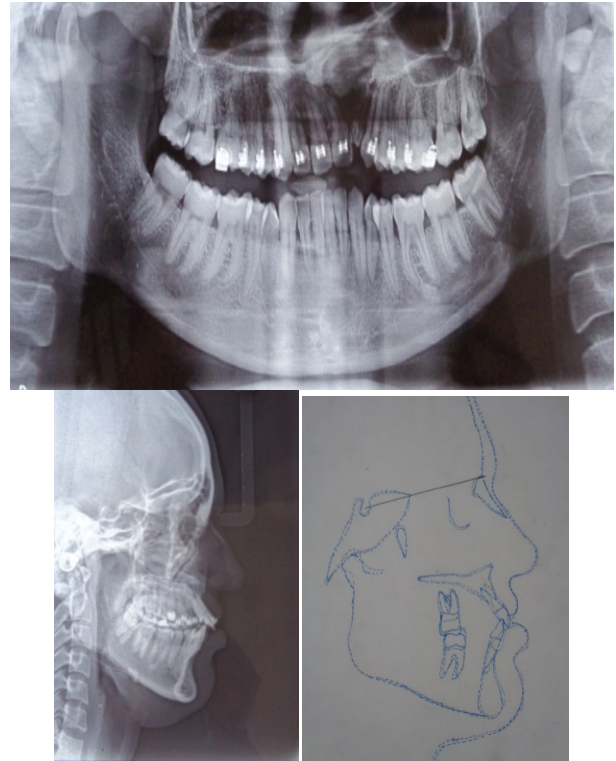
Posttreatment radiographs and superimposed tracings. Black, pretreatment; blue, midtreatment.
